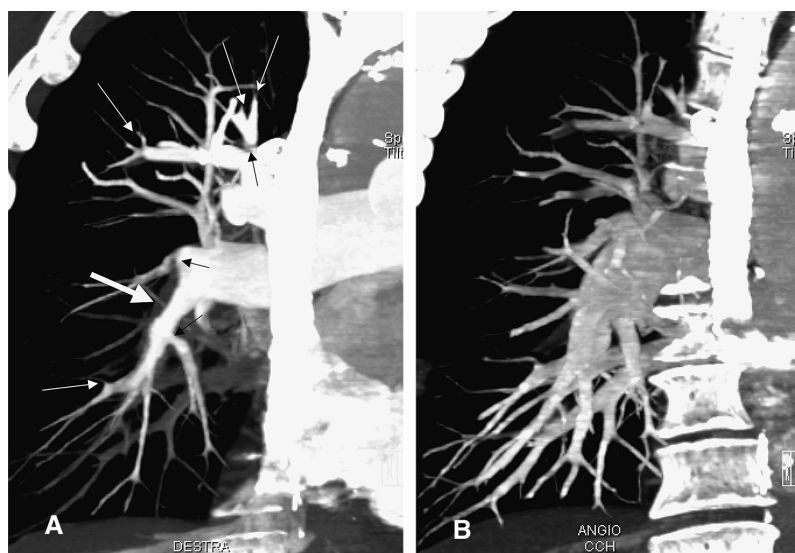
Maximum intensity projection reconstructed images of multidetector computed tomography in chronic embolic pulmonary arterial hypertension before (A) and after (B) surgery. Thrombus in the right descending pulmonary artery (thick arrow); proximal stenosis and dilations of the segmental arteries (black thin arrows); subsegmental occlusions (white thin arrows) and diffuse narrowing in the peripheral arteries. Normal findings after surgery (B).
